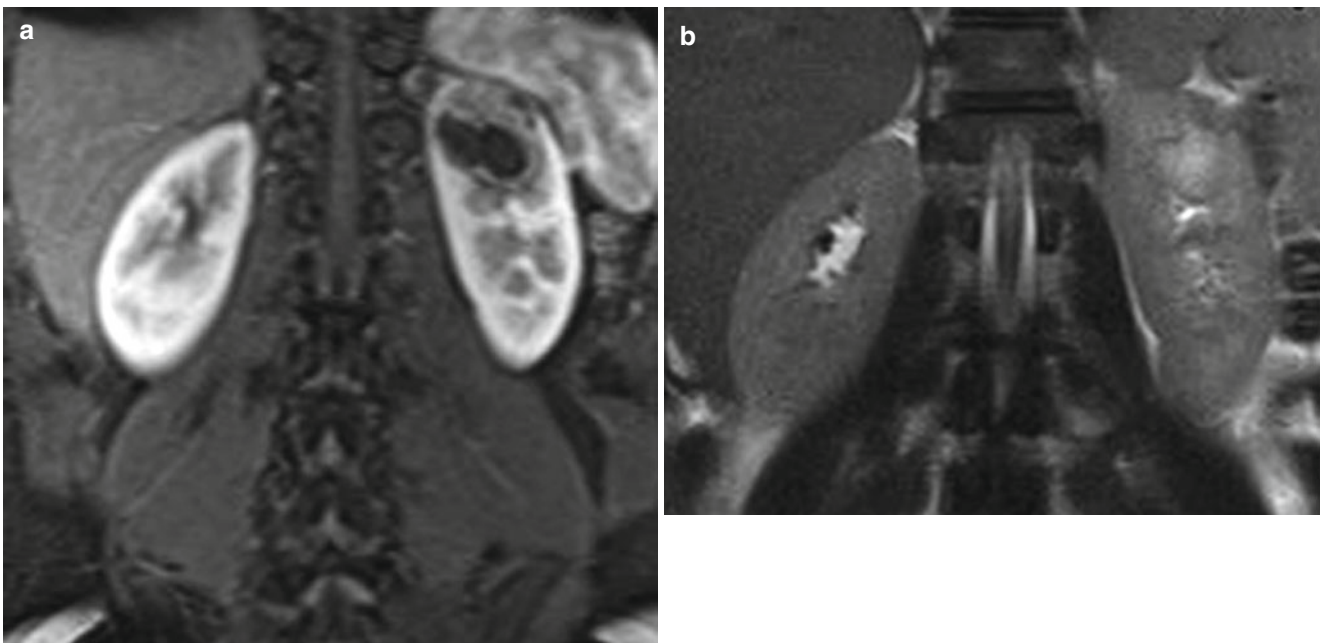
Right renal abscess on MRI in an 18-year-old female with left upper quadrant pain and elevated WBC. (a) Contrast-enhanced T1-weighted coronal image demonstrates peripherally enhancing
